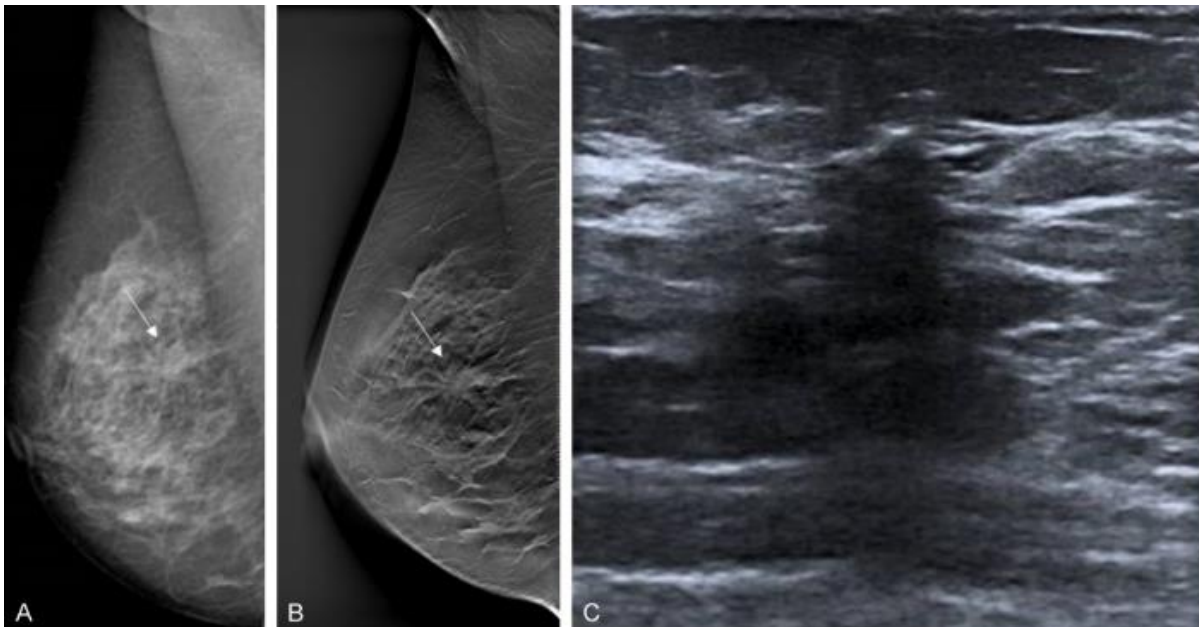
Mediolateral oblique digital mammography view (A) shows structural distortion (arrow) on the heterogeneously dense breast. On digital breast tomosynthesis (B), A spiculated mass (arrow) was detected at the center of the right breast and assessed as category 5. On ultrasound (c), a hypoechoic area with blurred contours was observed and assessed as category 4B. The mass was confirmed as sclerotic tissue (retrieved from Emlik et al., 2017)
